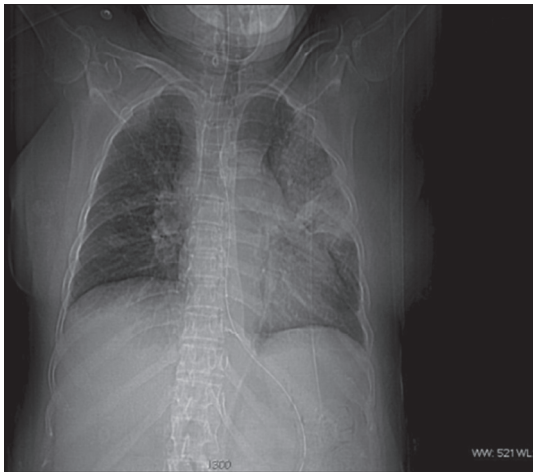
Chest X-ray showing left lingular lobe and upper lobe nonhomogenous infiltrates
